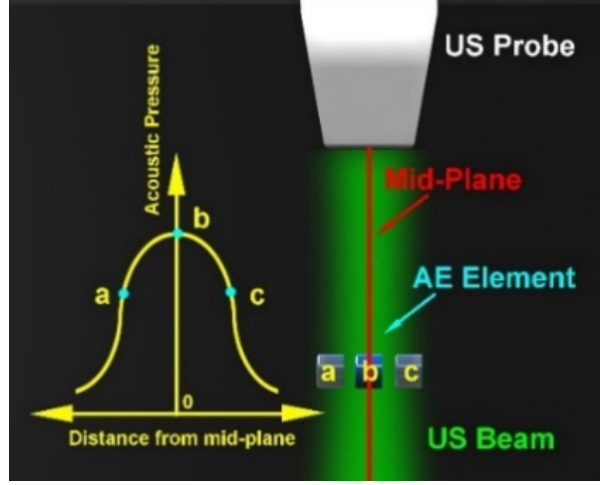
The main concept in using an AE element for mid-plane localization. At position b, AE element receives the maximum ultrasound signal amplitude. At a and c, although the element is still shown US image, the received signal amplitude is lower compared to b.
